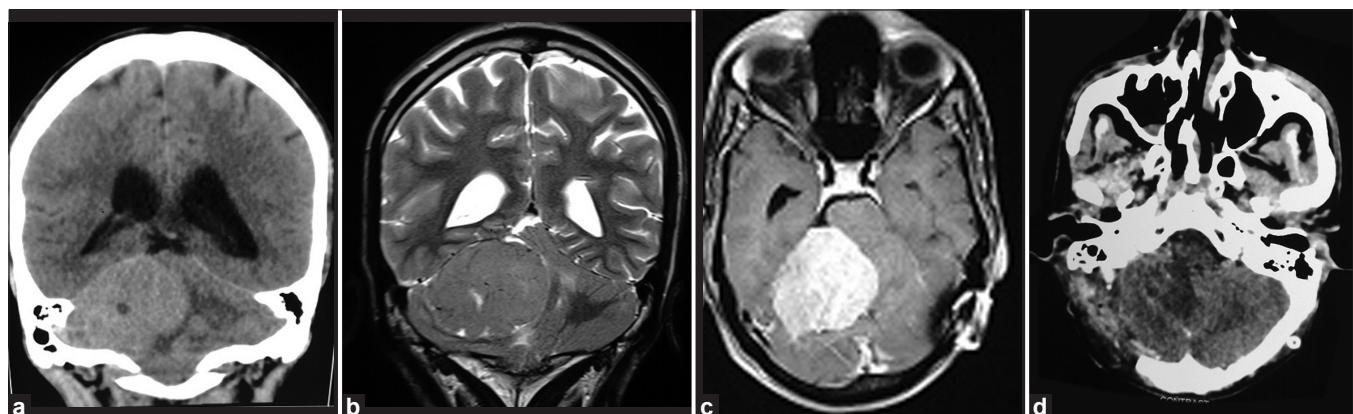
Right CP angle meningioma with post operative CT scan s/o retromastoid craniectomy defect with gross total excision
